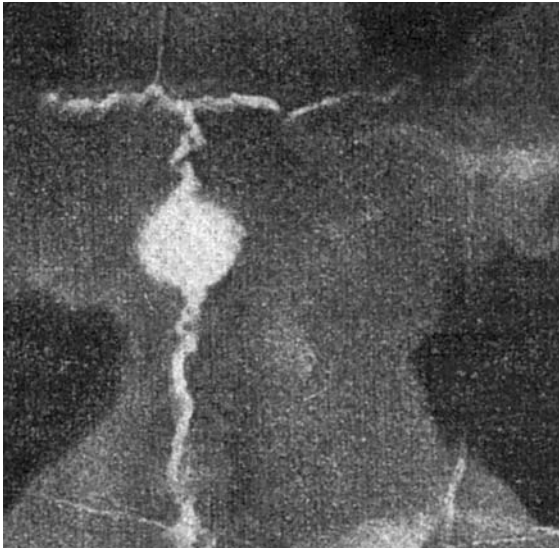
Radiograph of the trepanation from individual No. 54 from the cemetery of Vovnigi II, highlighting the absence of remodelled bone (Gokhman, 1966). Used with permission of the author.
